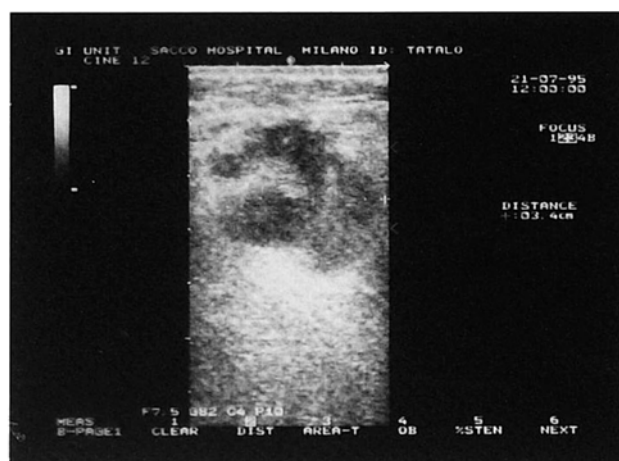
Ultrasonographic appearance of an abscess of anterior abdominal wall. It is a round anechoic lesion with internal echoes, irregular wall, and posterior echo enhancement.
